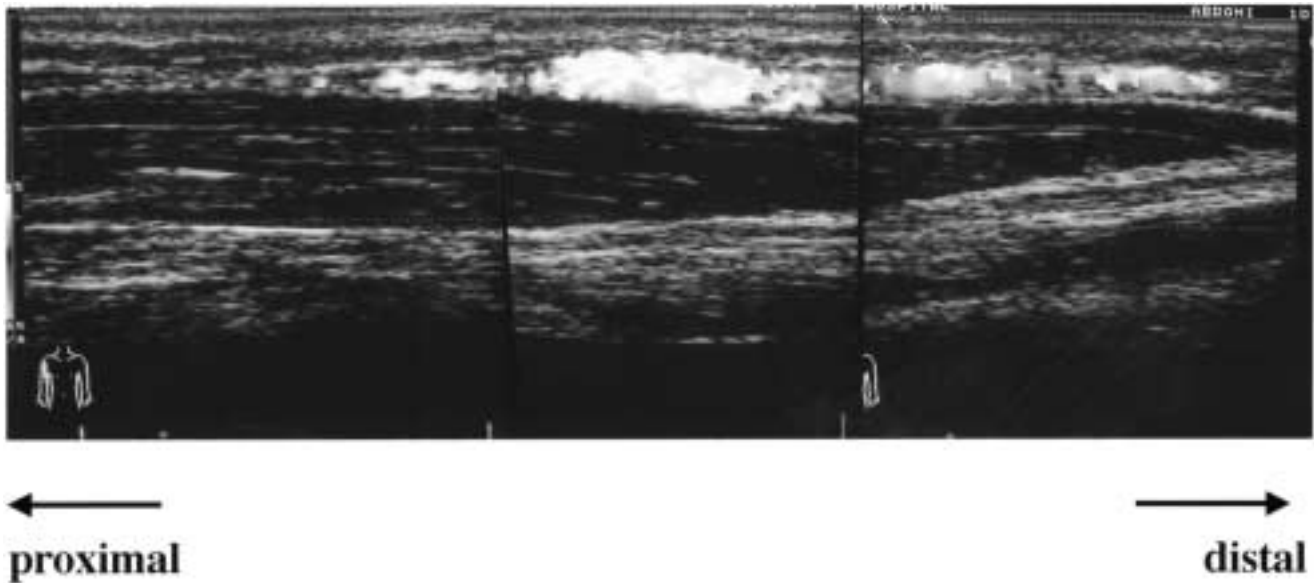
Color doppler ultrasound scan revealed a 2 cm vascular mass on a dilated vein with fast blood flow and no communication between the arteries and veins was detected.
